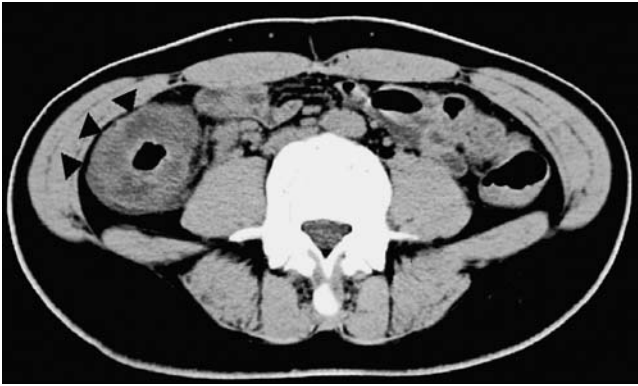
Computed tomographic features (target sign, triangles) of colonic wall thickening (ascending colon) in enterohemorrhagic *Escherichia coli* (EHEC) colitis
